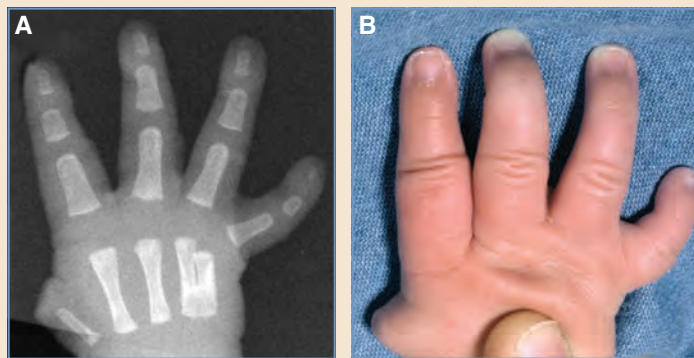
Brachymetacarpia with associated fusion of the fifth metacarpal to the adjacent fourth metacarpal in a patient with thumb hypoplasia. A, Posteroanterior radiograph of the right hand. B, Right hand.
